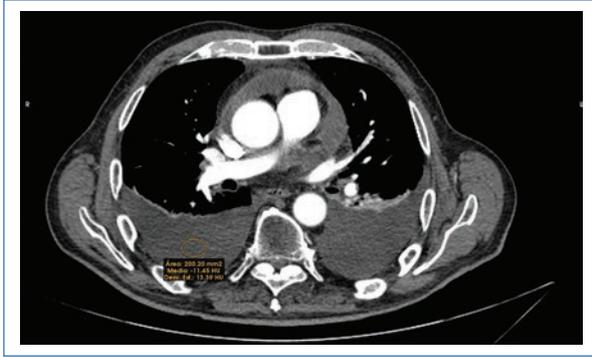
Contrast-enhanced CT showing a median fluid attenuation value of -11.45 HU (circle) in a patient with acute pleuro-pericarditis.
